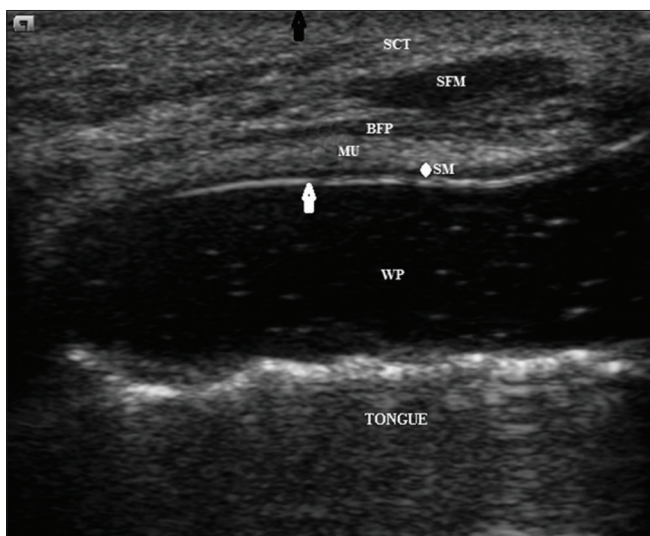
B-mode image for normal mucosa with ultrasound
